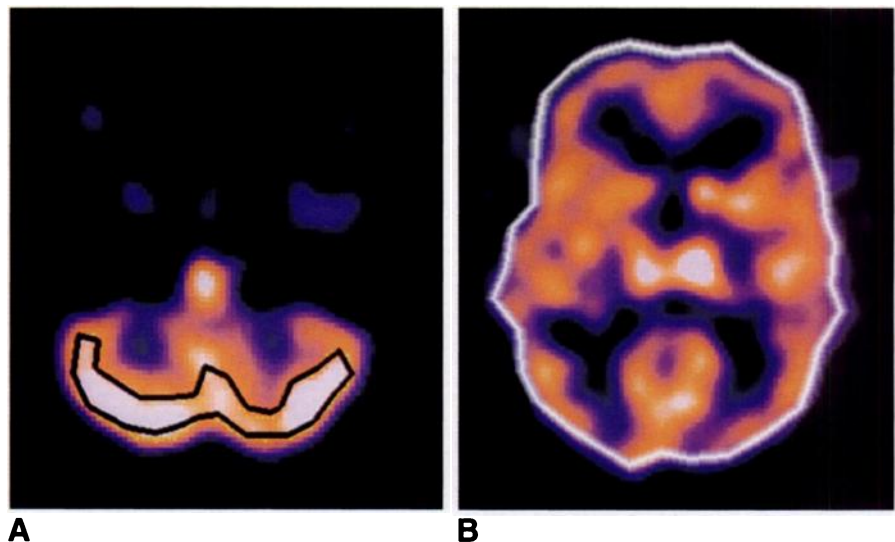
A and B, Axial SPECT images of a patient with chronic fatigue syndrome show regions of interest (ROIs) used to calculate mid-cerebral uptake index (MCUI). ROIs have been drawn around cerebellar cortex of a 5-mm section obtained at midcerebellar level (A) and around perimeter of a 1.5-cm slab obtained at midcerebral level (B). Counts per pixel of mid-cerebral ROI were divided by counts per pixel of cerebellar ROI to yield the MCUI.
